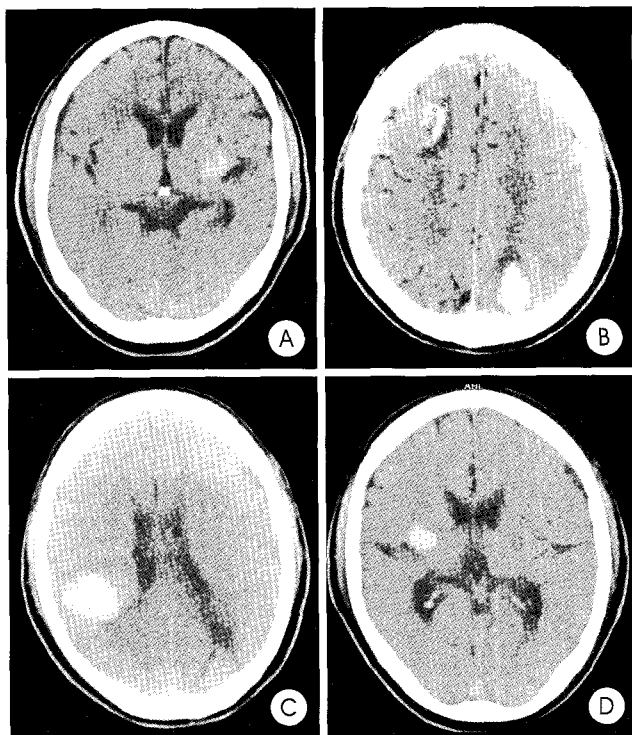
A : Computed tomography showing left basal ganglia hemorrhage with symptoms of slurred speech and hemiparesis 9 years before last event. B : Left occipital and right frontal lobar hemorrhage developed 7 years after initial hemorrhage. C : Computed tomography showing the third event of hemorrhage in the right parietal lobe 8 years after initial event. D : The last hemorrhage event in the right basal ganglia.
